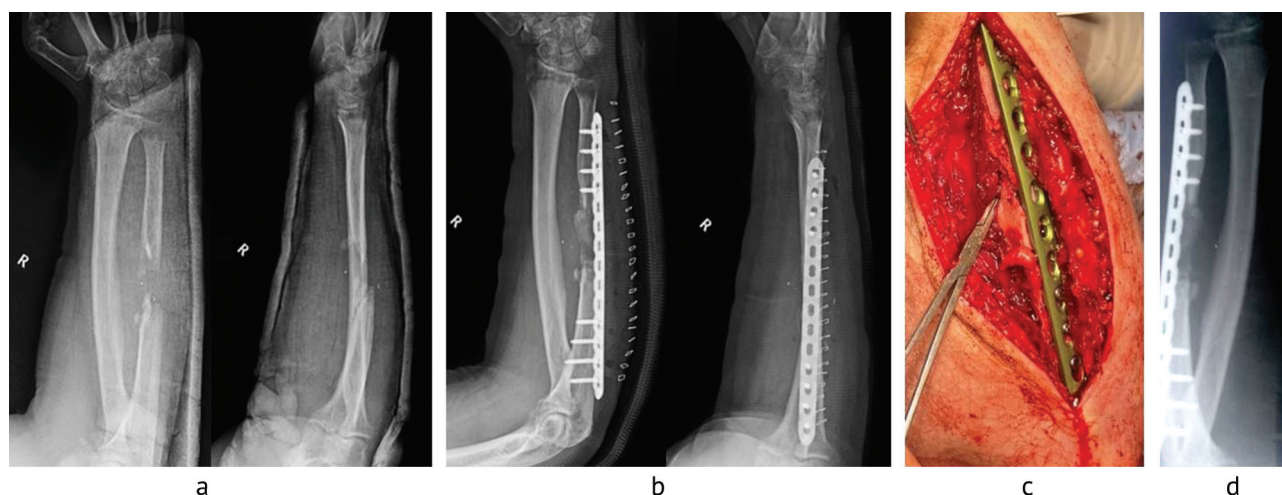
Injured male G., radiographs of forearm bones: *a* before surgery; *b* after the surgery; *c* an intra-operative view of the wound, osteosynthesis and cancellous graft from the iliac crest; *d* at 6 months after the surgery
